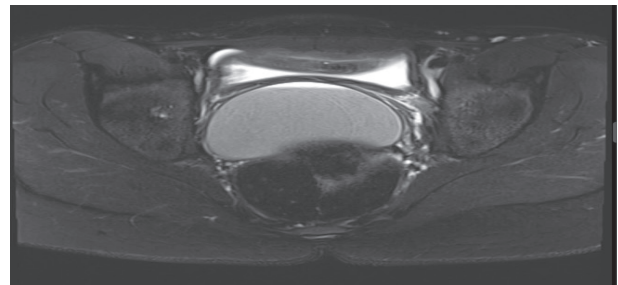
Fat Suppression MRI, Axial View
